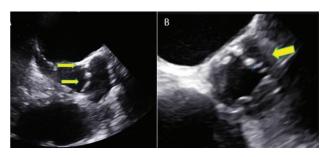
Transesophageal echocardiogram A. Long axis view showed vegetations on the non coronary cusp (3.42mm) and right coronary cusp (2.40mm). B. Short axis view showed vegetation on the left coronary cusp
